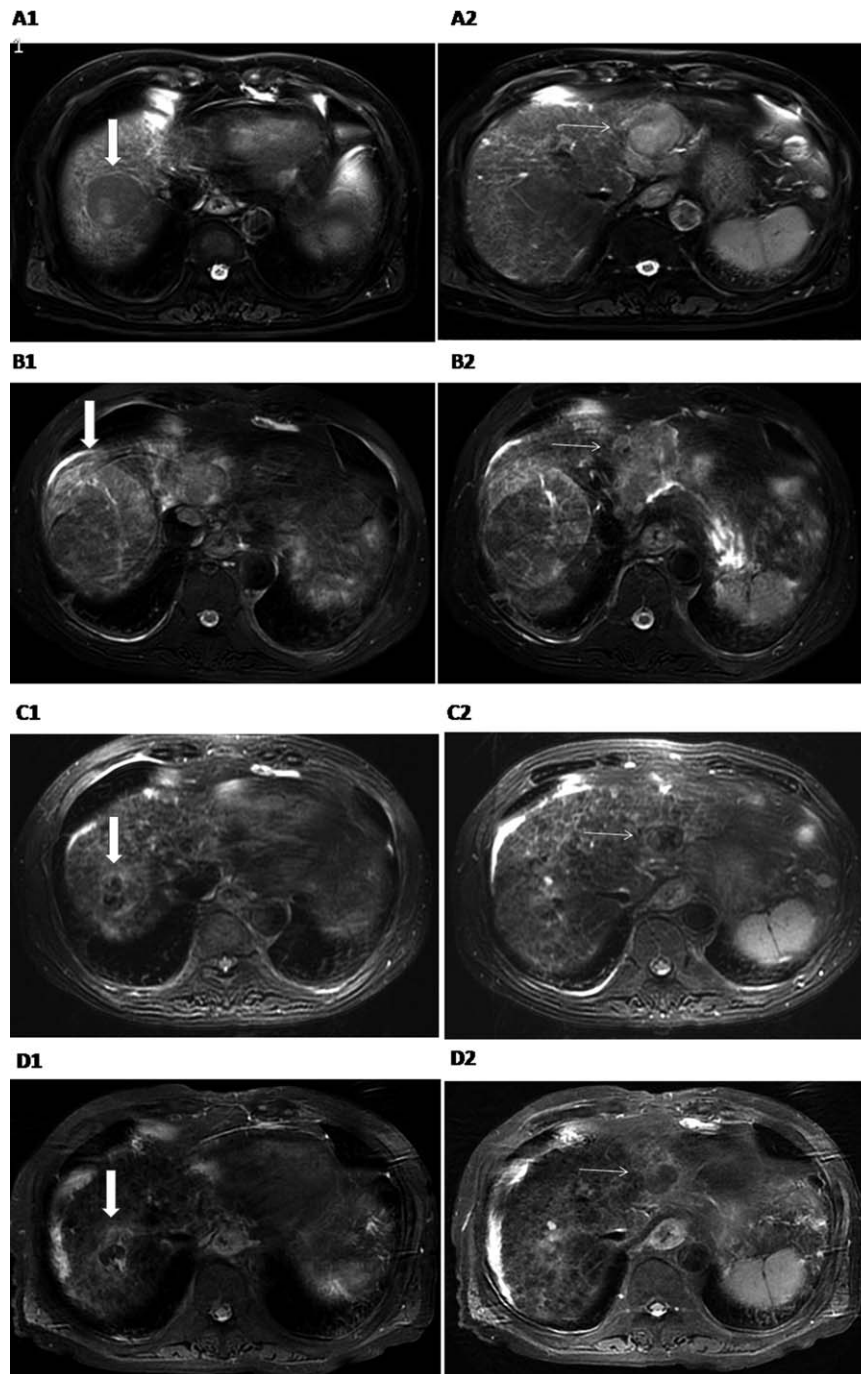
Magnetic resonance imaging scans (T2WI) depicting lesions in the right liver lobe (A1, B1, C1, and D1, thick arrow) and the left liver lobe (A2, B2, C2, and D2, thin arrow). Magnetic resonance imaging scan showing diagnosis (A), pretreatment (B), posttreatment (C), and present state (D). A significant reduction in the lesions was noted from B to D. CR was achieved. CR=complete remission, T2WI=T2-weighted image.
